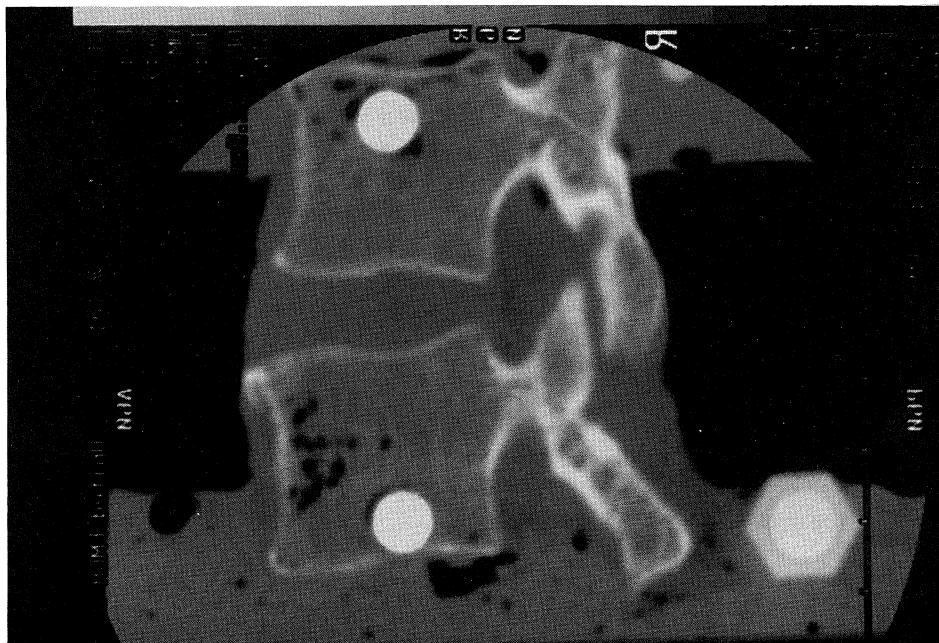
The parasagittal CT
